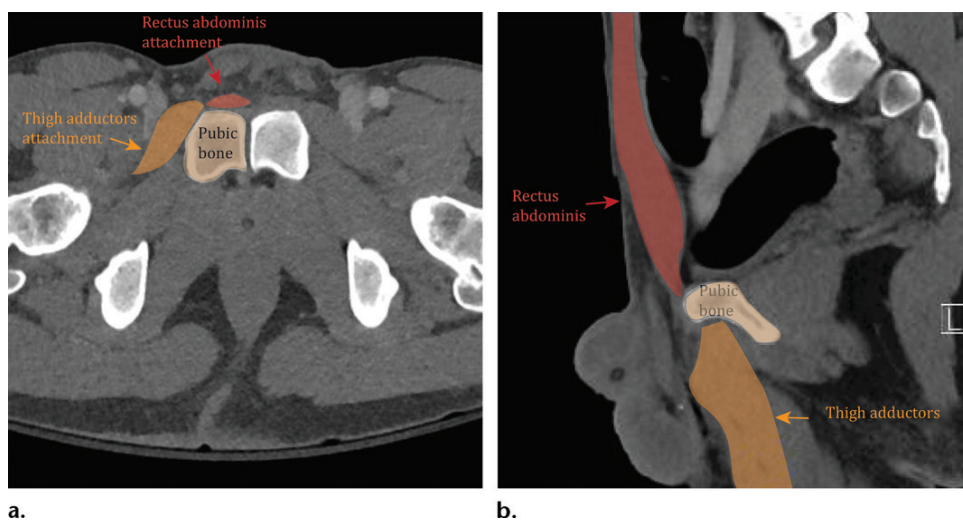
Anatomy of the pubic symphysis. Annotated axial (a) and sagittal (b) CT images show the superomedial insertion of the rectus abdominis and the more lateral and inferior insertion of the adductor tendons of the hip. These two insertions are the most common sites of injury in athletic pubalgia.
